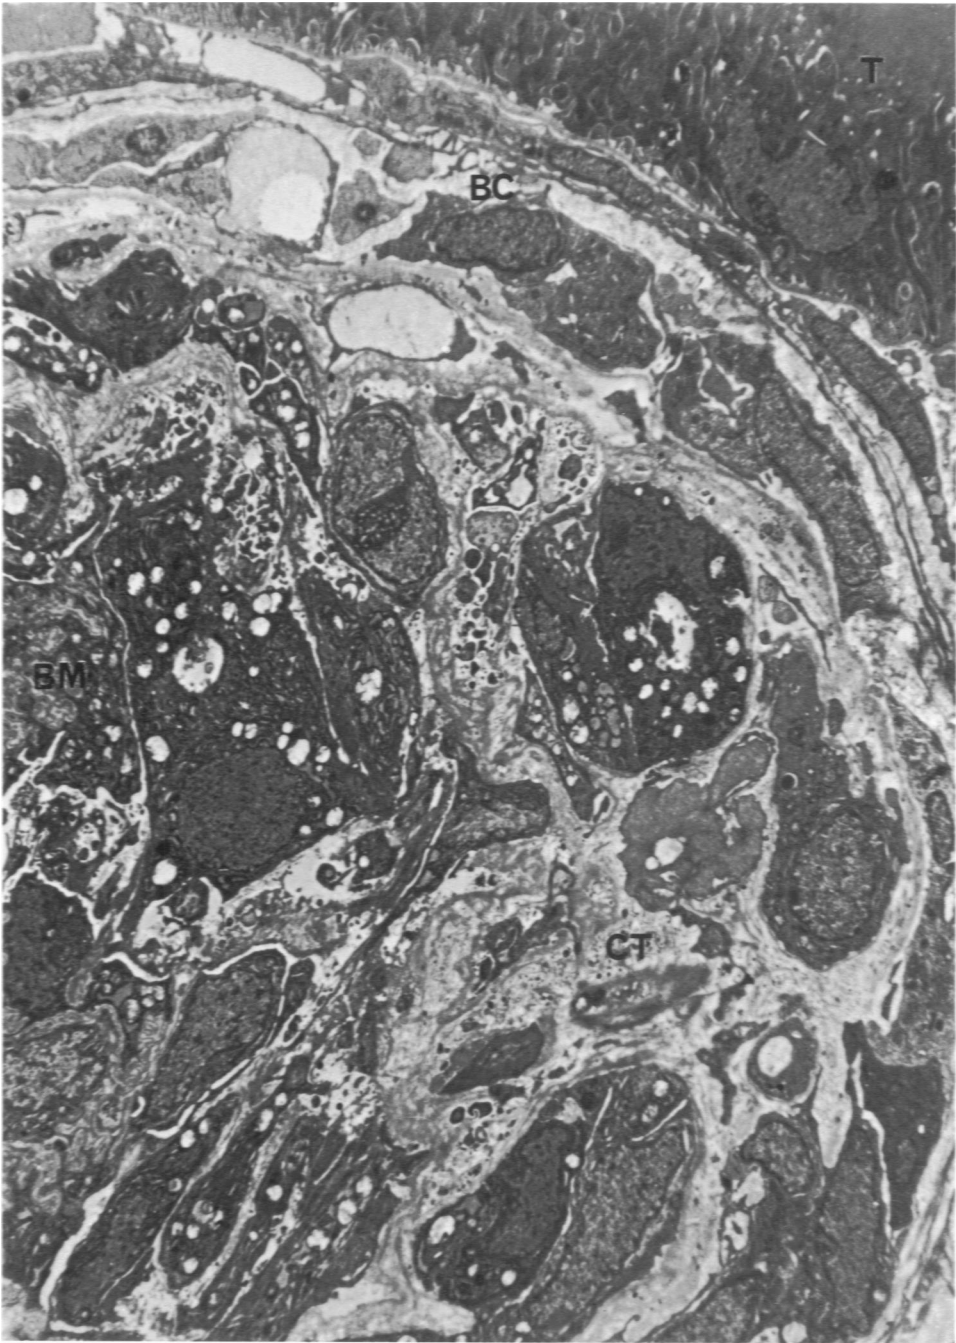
Nephrotic nephritis. Glomerulus 18 days after injecting anti-kidney antibody. The capsular space is filled with inflammatory cells, fibroblasts and epithelial cells with strands of collagen and fibrin interspersed (A crescent, $\times 2800$). *T* = Tubular cell; *BC* = Bowman's capsule; *CT* = Connective Tissue; *BM* = Wrinkled collapsed capillary basement membrane.
